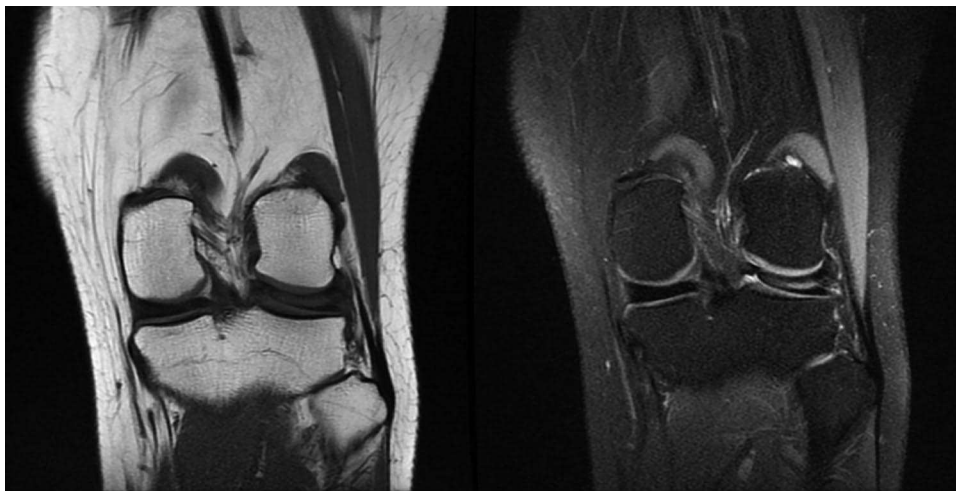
Magnetic resonance imaging (MRI) coronal views of the knee of a 15-year-old girl. T1 (left) and FAT SAT (right) showing a lateral discoid meniscus with a concomitant horizontal tear.
